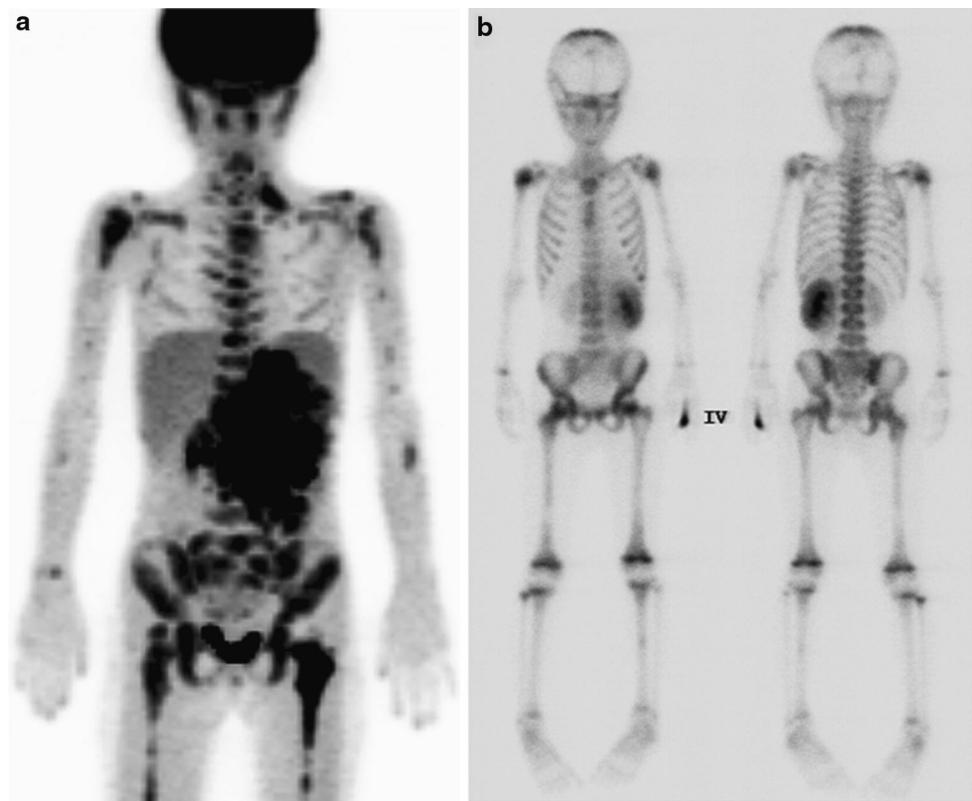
Images of a 5-year-old girl with stage 4 neuroblastoma. This patient was confirmed bone metastases by bone marrow biopsy at bilateral iliac crests. a ^{18}F -FDG PET anterior maximum-intensity projection image demonstrates diffuse intense uptake in axial and proximal appendicular skeleton. b Anterior and posterior bone
